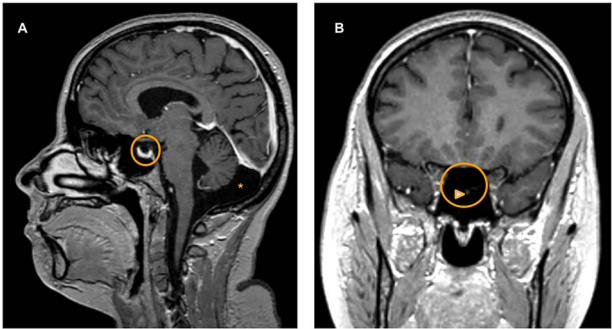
Brain magnetic resonance imaging T1-weighted images without contrast on sagittal (A) and coronal (B) plane demonstrate an empty sella (circle) filled with cerebrospinal fluid with no visualization of the pituitary gland. However, the pituitary stalk can be visualized (arrow in B). Sagittal image also shows mega cisterna magna (asterisk in A).
